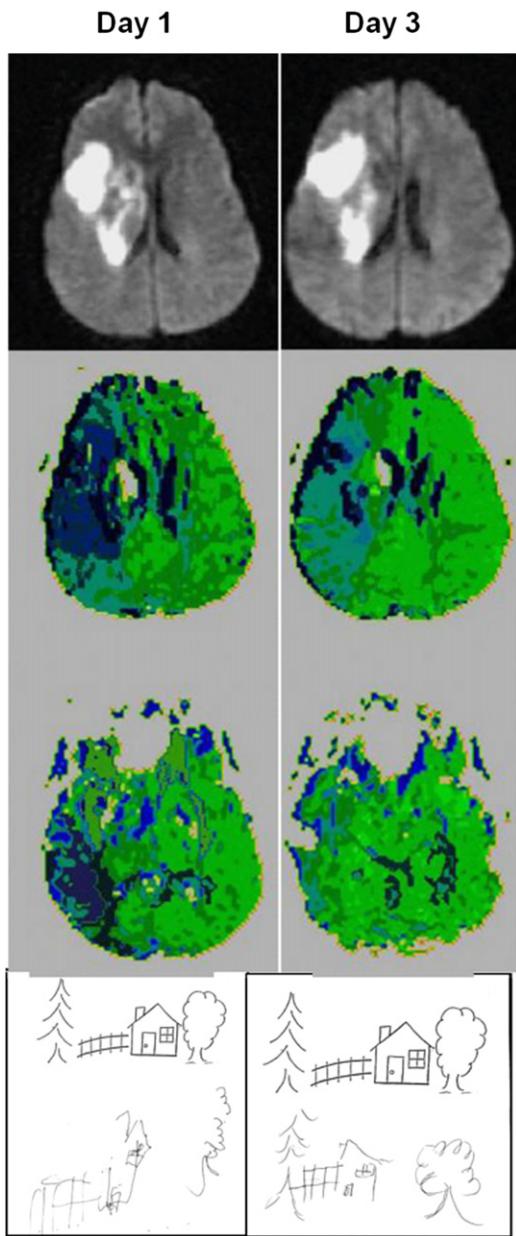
Top panel: DWI scans at Day 1 (left) and Day 3 (right) of Case 3. Middle 2 panels: PWI scans at Day 1 (left) and Day 4 (right) of Case 3. Lowest panel: Copy of the scene at Day 1 (left) and Day 4 (right) by Case 3.
